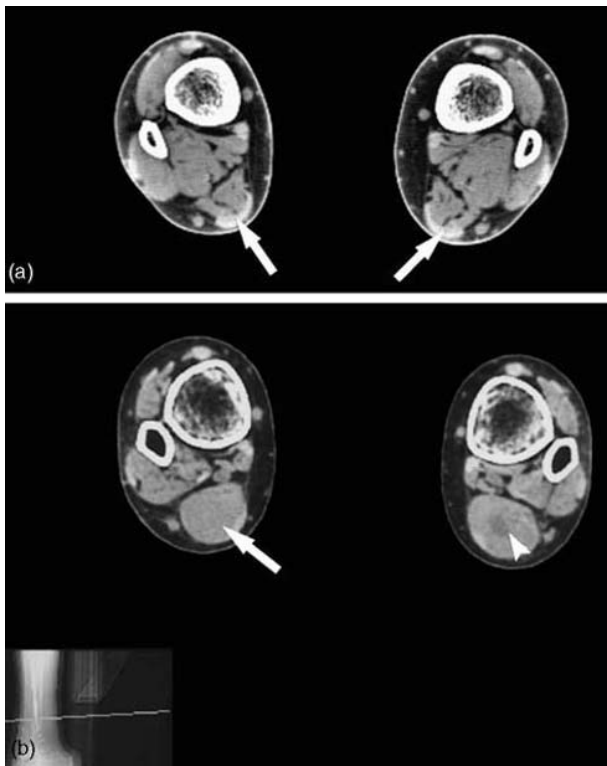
Cross-sectional CT images of Achilles tendon: (a) the normal appearance of the narrow crescent-shaped tendon (arrows). (b) The abnormal markedly thickened tendons of a CTX patient (arrow). Note the central hypodense area representing lipid accumulation (arrowhead).
